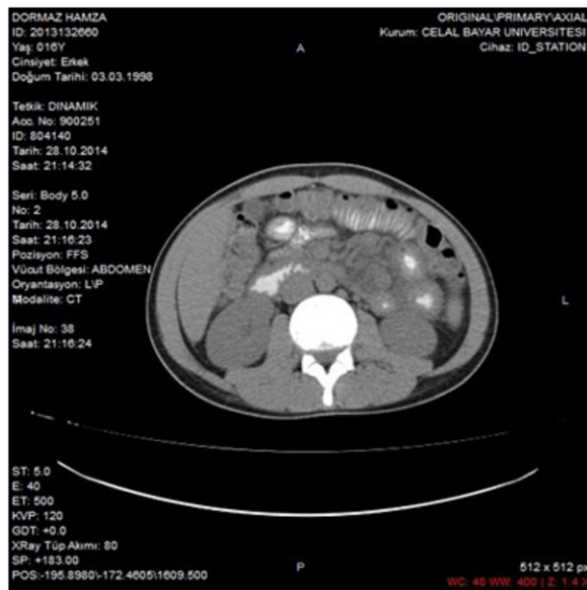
Increase in wall thickness of the patient in jejunum and ileum presented by abdomen CT.
